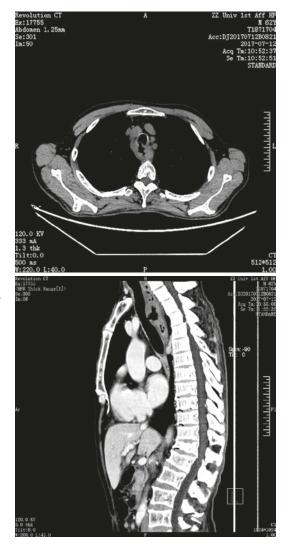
Esophageal-tracheal fistula display on CT scan
